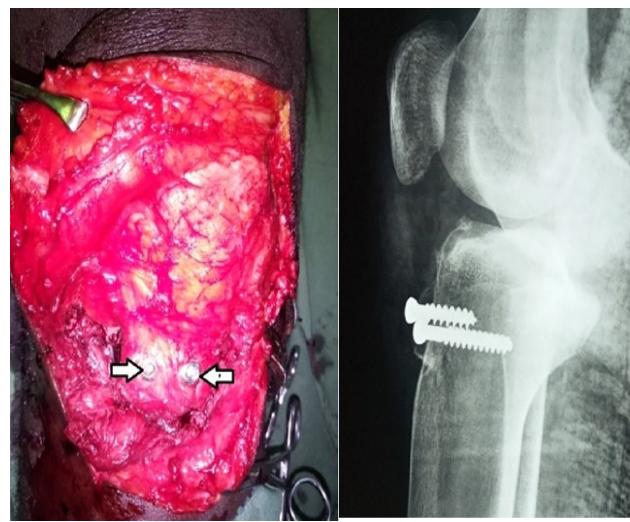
Photograph showing intra-Op fixation of the tubercle and immediate post-OP X-Ray
